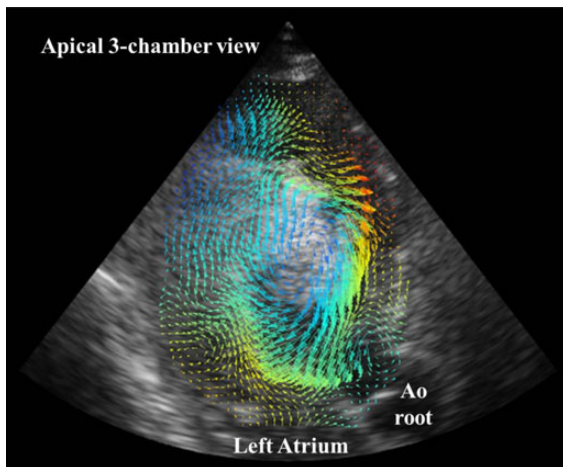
Example of the left ventricular fluid dynamics assessed by Echocardiographic Particle Image Velocimetry (Echo-PIV). This approach looks very promising to optimize the mode of pacing in patients implanted with a bi-ventricular pace maker and with a left ventricular multi-pole lead.
